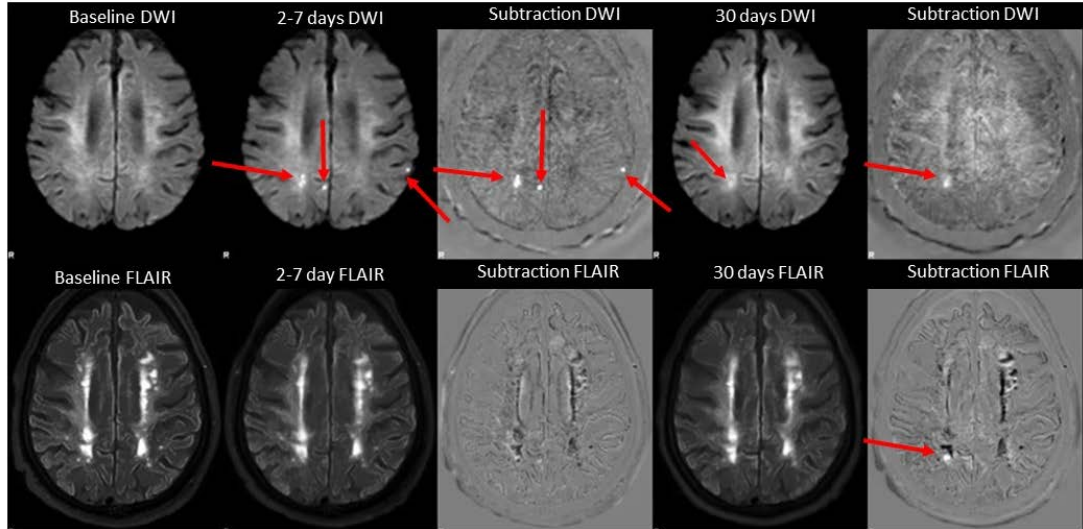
MRI Analysis Images
